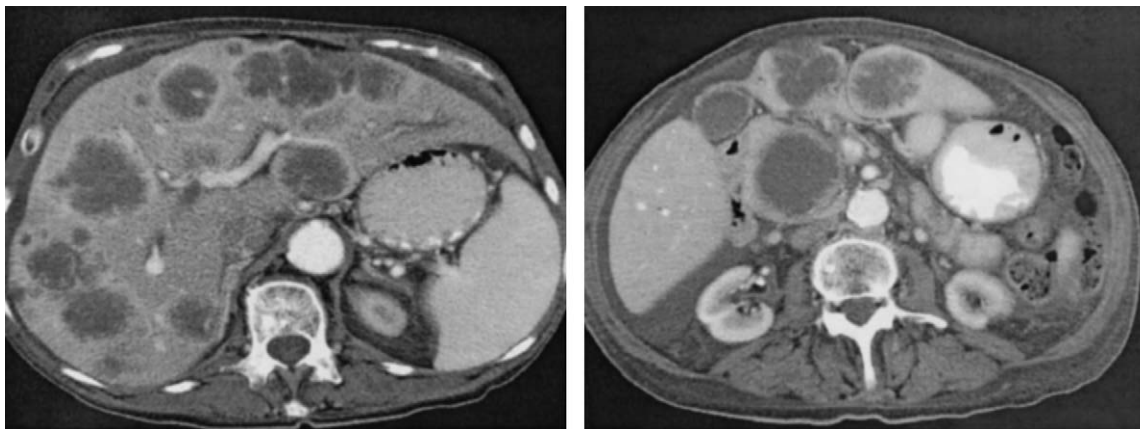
CT scan of a patient with metastatic pancreatic cancer, with diffuse liver involvement. (Courtesy of Saroja Adusumilli, Department of Radiology, The University of Michigan Medical Center).
